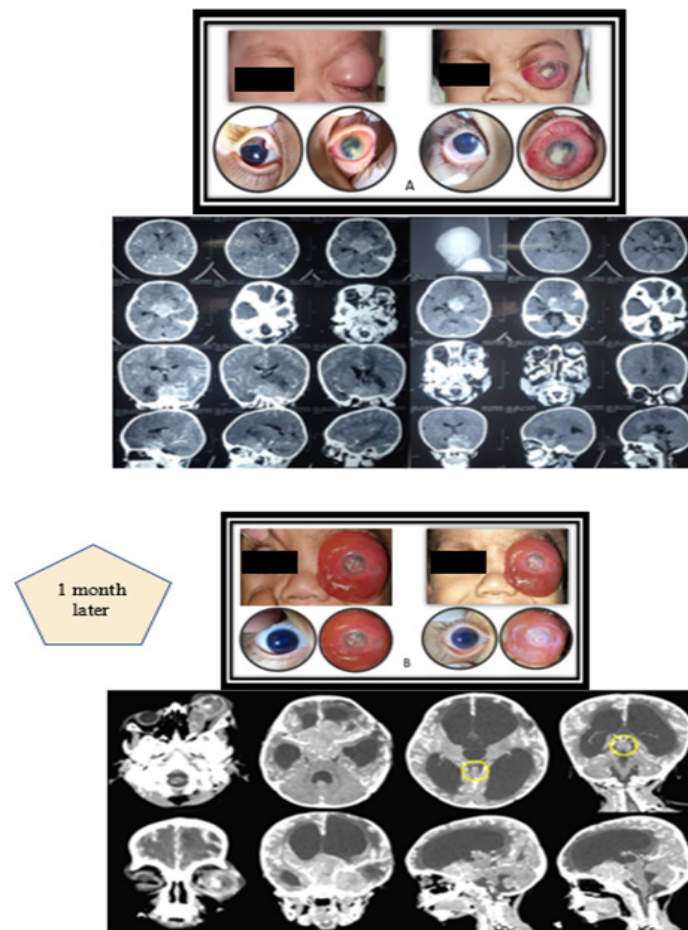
(A) At 2 months of age, there was swelling in the left eyeball and a reddish bulge. Contrast head CT imaging showed an endophytic mass with a calcified component on the right orbital, extending to the suprasellar gland and causing pineal gland enlargement. (B) One month after craniotomy surgery, the left eye became more prominent and swollen, with a reddish bulge that persisted for the last 5 days. Contrast head CT imaging showed an enlarged suprasellar mass (axial diameter ± 6.23 cm) that had extended to the pineal gland, resulting in pineal gland enlargement ($\pm 10.6 \times 16.4 \times 15.5$ mm) with contrast enhancement (indicated by the yellow circle) and communicating hydrocephalus.
